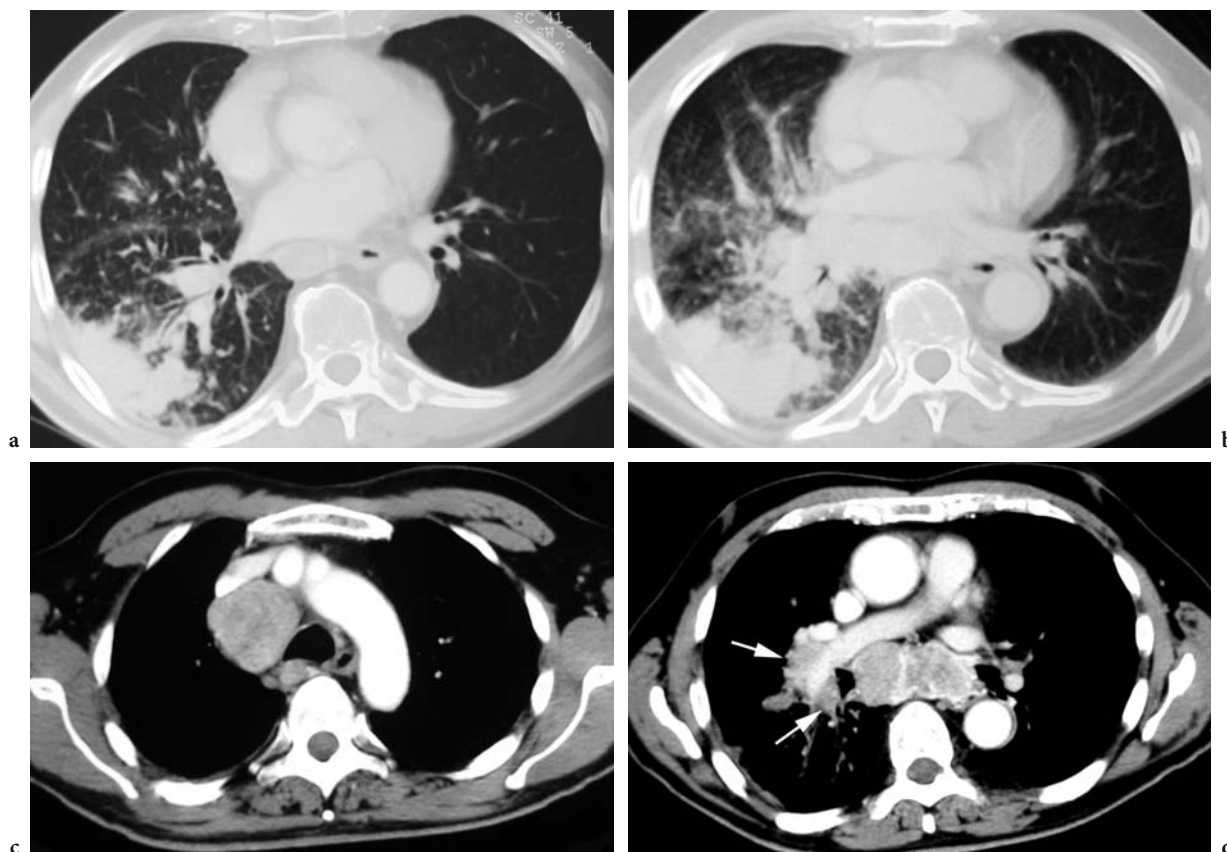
Pulmonary lymphangitic carcinomatosis and mediastinal lymph node metastases in a 48-year-old man who underwent nephrectomy for renal cell carcinoma. a Axial CT scan shows right inferior lobe with ill-defined parenchymal consolidation surrounded by thickened nodular, interlobular septa forming polygonal arcades, indicating an interstitial lymphangitic disease. There is also a mild enlargement of the right hilar lymph nodes. b Two-month follow-up axial CT scan shows worsening of the pulmonary consolidation, interstitial disease, and right hilar lymph nodes. c, d Axial contrast-enhanced CT scans show enhancement at different intensities of enlarged (c) right lateral tracheal, (d) subcarinal and right hilar (*arrows*) lymph nodes.
